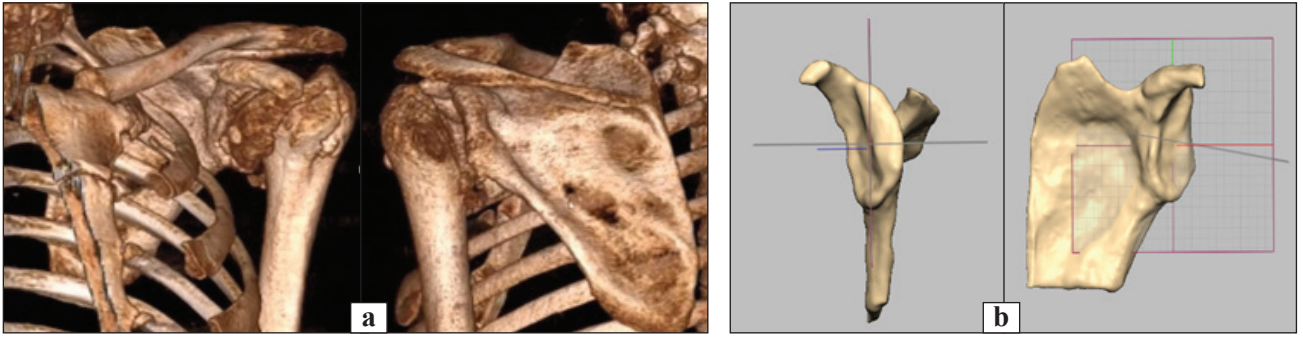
CT reconstruction of the shoulder joint (a) and 3D reconstruction of the joint cavity of the scapula (b) in a 52-year-old patient B.
